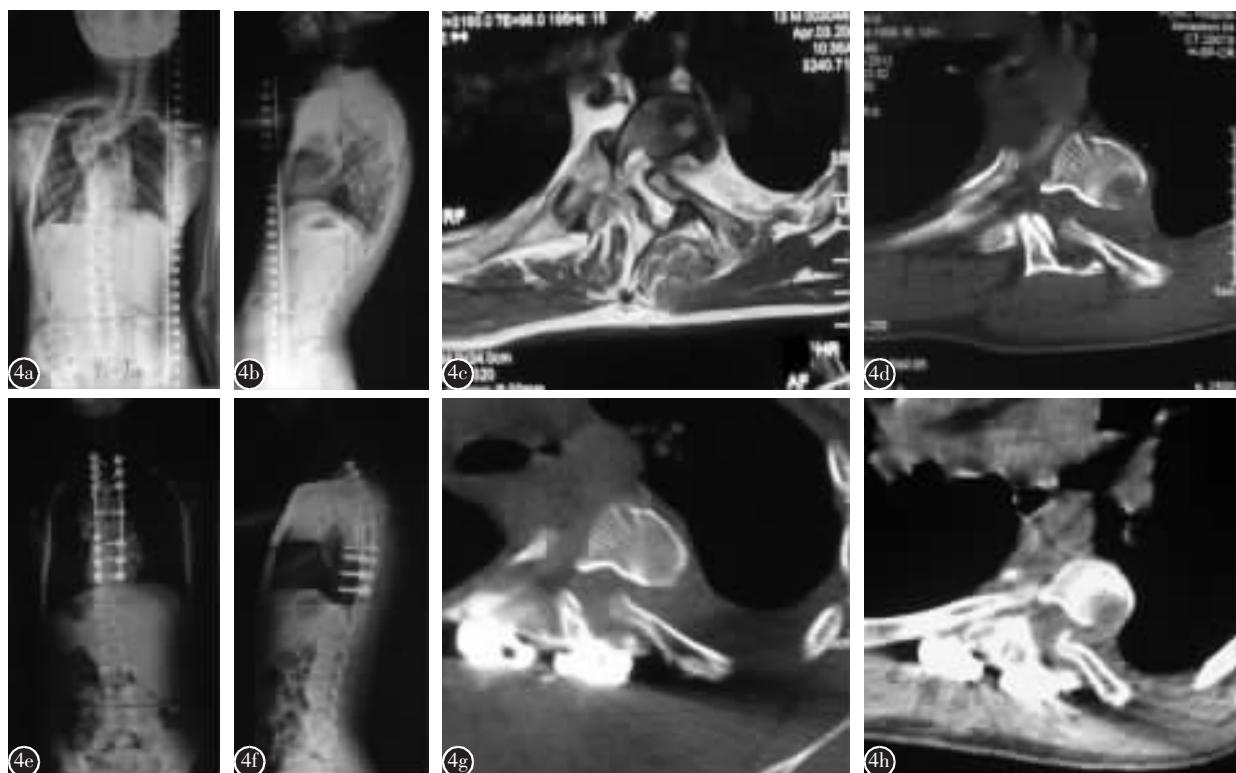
患者男,13岁,发现全身多发咖啡斑 12 年,背部不平 5 年余,加重伴胸前区痛 3 个月,查体:胸段左侧后凸,右侧踝阵挛阳性,右侧 Babinski 征(+),ASIA 分级 D 级 a 术前脊柱正位 X 线片示患者胸段侧凸向左侧 b 术前脊柱侧位 X 线片示患者胸段局限性后凸 c、d 术前 MRI 及 CT 示肋骨在 T8 平面从左侧椎间孔凸向椎管, 肋骨头过椎管矢状位中线 e 脊柱后路矫形 CDH M8 椎弓根螺钉内固定、混合骨植骨融合术(T1~T10), 术后脊柱正位 X 线片示冠状面矫形效果良好, 躯干偏移得以纠正 f 术后脊柱侧位 X 线片示胸后凸矫形效果良好 g 术后肋骨在 T6 平面从左侧椎间孔凸向椎管, 肋骨头在椎管内回复至中线附近 h 术后 1 年随访, 肋骨头在椎管内位置和术后情况相近, ASIA 分级 D 级
